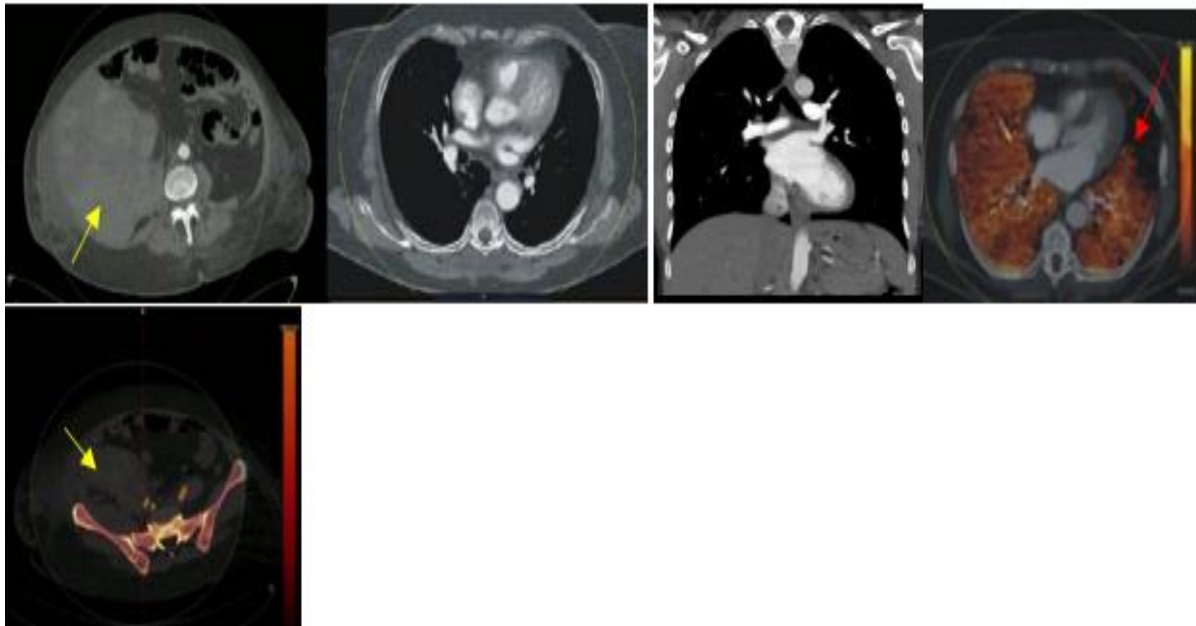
55 years old patient went under bone biopsy from pelvis and new large mass at lower abdomen huge hematoma noted at CT scan (yellow arrow) CT angiography normal iodine mapping showing filling defect at lingula (red arrow).
